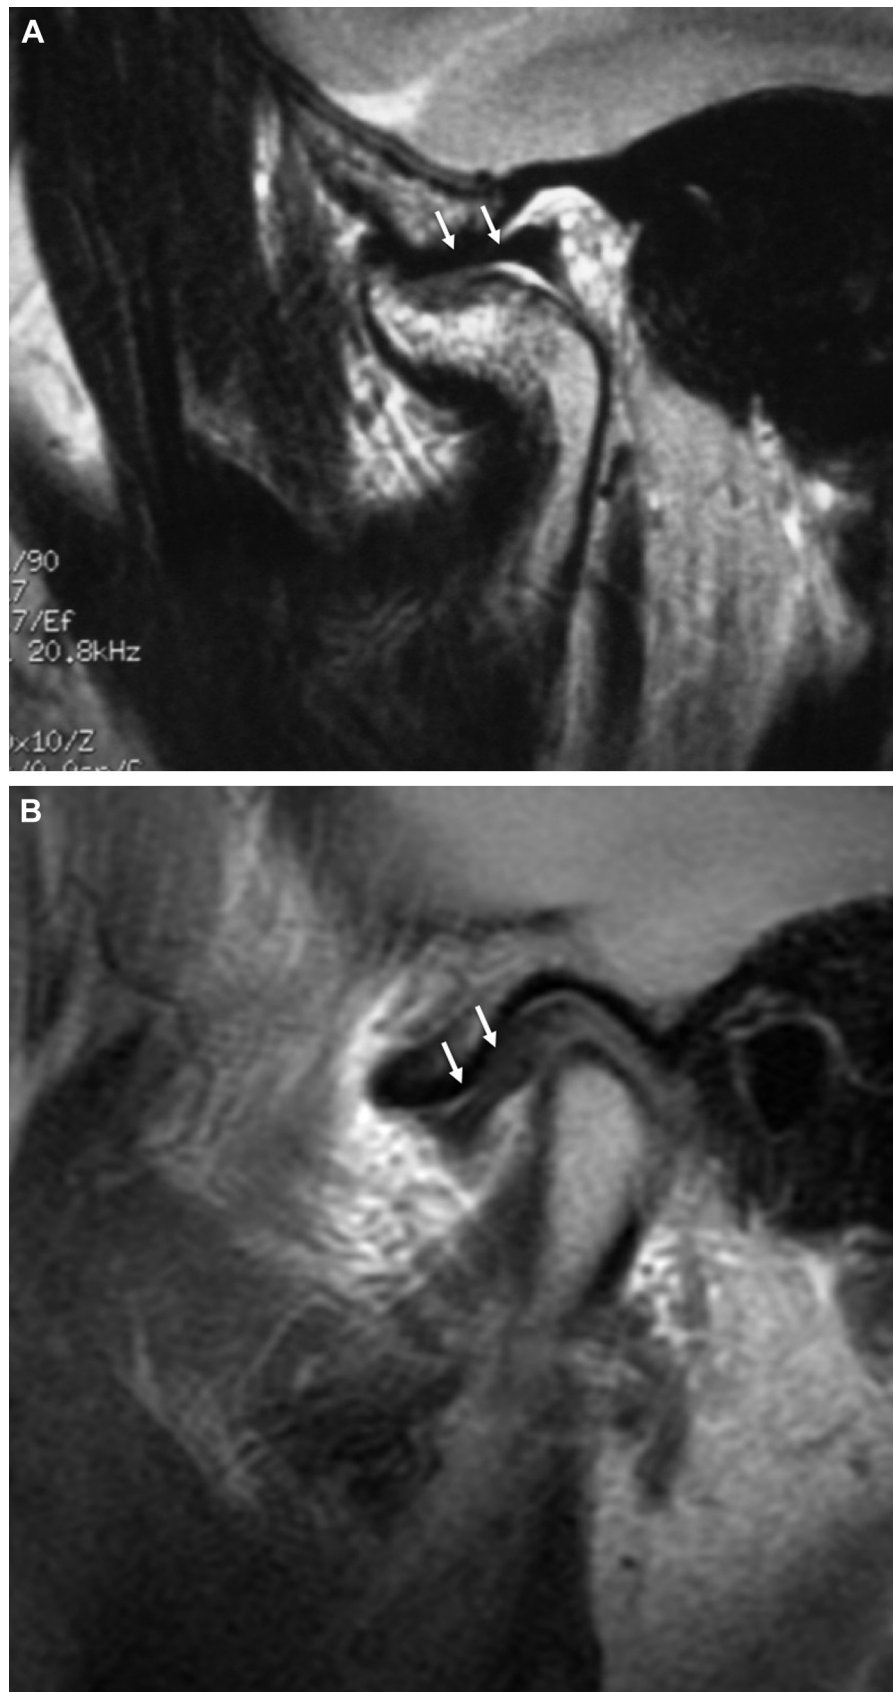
Magnetic resonance imaging scans. A, The ipsilateral osteochondroma, although quite large, shows that the articular disc is still in position (arrows). The width of the condylar neck is increased. Note the disarticulation of condyle downward out of the fossa from the exophytic tumor growing forward beneath the articular eminence. B, The contralateral joint shows a condyle that is smaller, with an anteriorly displaced disc (arrows). (Fig 4 continued on next page.)
